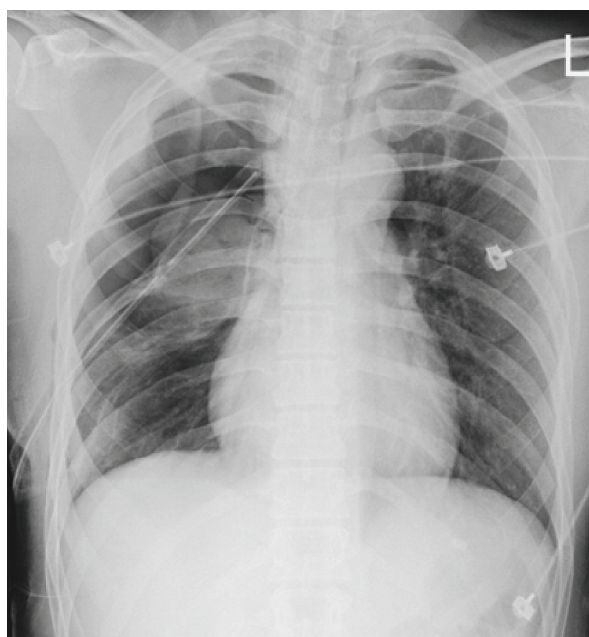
Chest radiograph showed multiple rib fractures, right pneumothorax and a chest tube inserted via the right 4th intercostal space.
